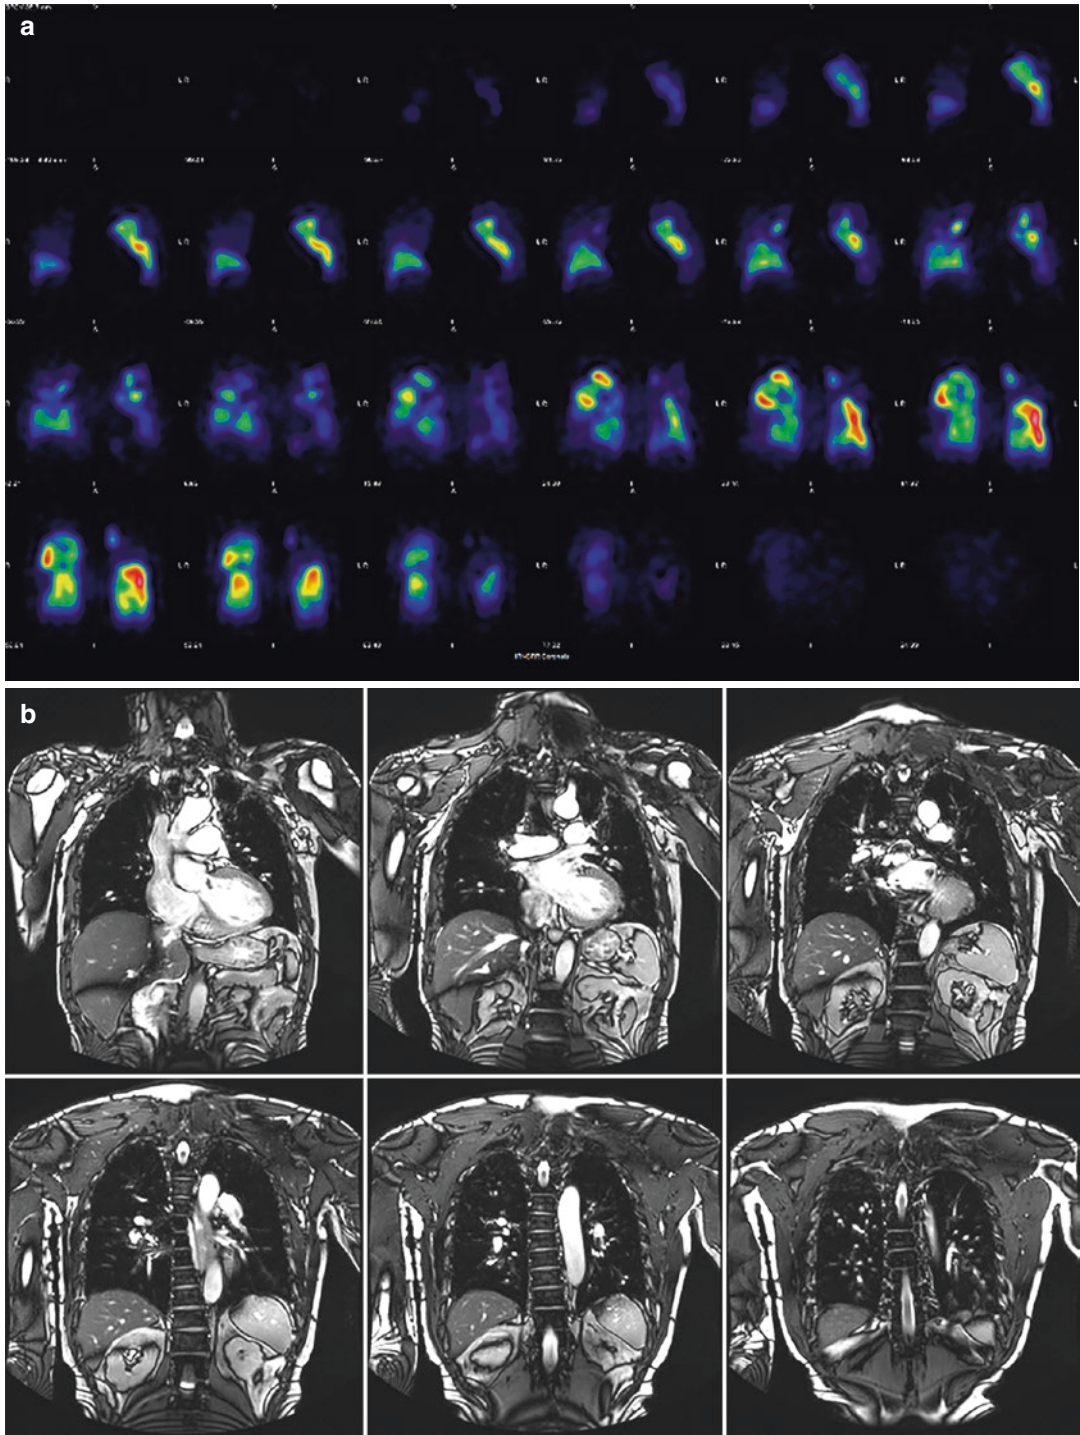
A 48-year-old male patient with chronic thromboembolic pulmonary hypertension. (a) Coronal reformat-perfusion SPECT images with ^{99m}Tc-MAA show heterogeneous parenchymal perfusion due to chronic pulmonary thromboembolism. (b) (Upper line images from ventral to central slices and lower line images from central
